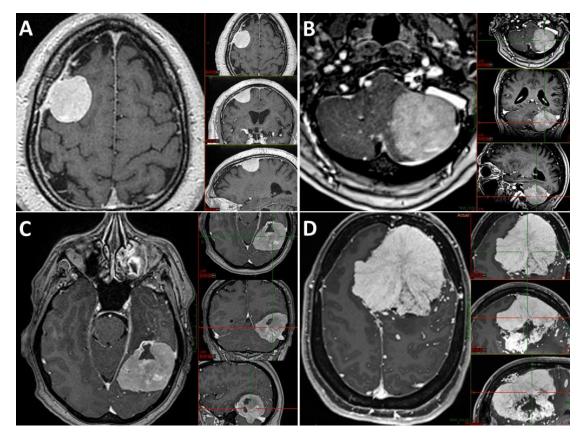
MRI images of 4 meningioma locations. A: supratentorial convexity (ACFA002) B: infratentorial/cerebellar convexity (ACFA008), 1C: tentorium cerebelli (ABFA008), 1D: parasagittal/ falx cerebri (ACFA028/ABFA010)
